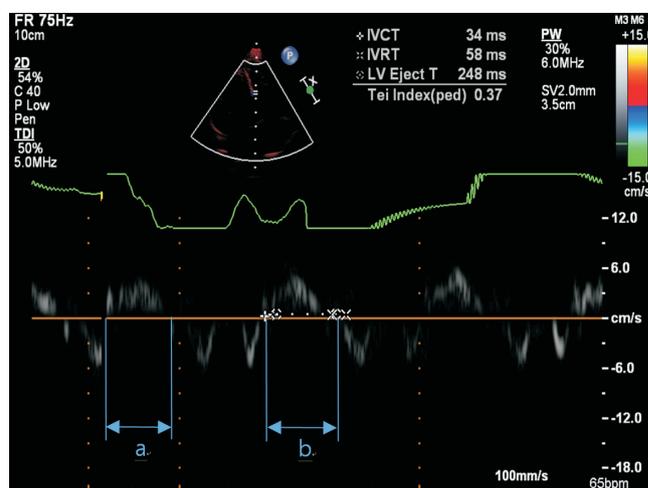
Tei index by tissue Doppler imaging in Kawasaki disease patient.  $Tei\ index = (a-b)/b = (IVCT + IVRT)/LVET$ . IVCT, isovolumetric contraction time; IVRT, isovolumetric relaxation time; LVET, left ventricle ejection time.
